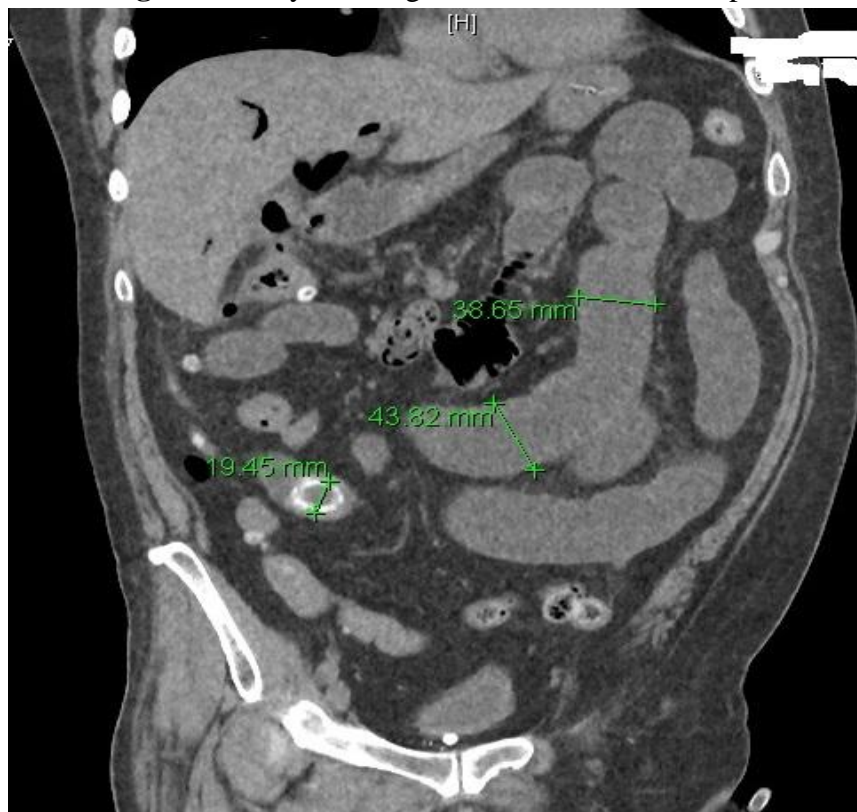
Axial view CT image showing a large gallstone impacted in distal small bowel with subsequent proximal dilatation of bowel. Air in the intra-hepatic biliary radicals noted.
